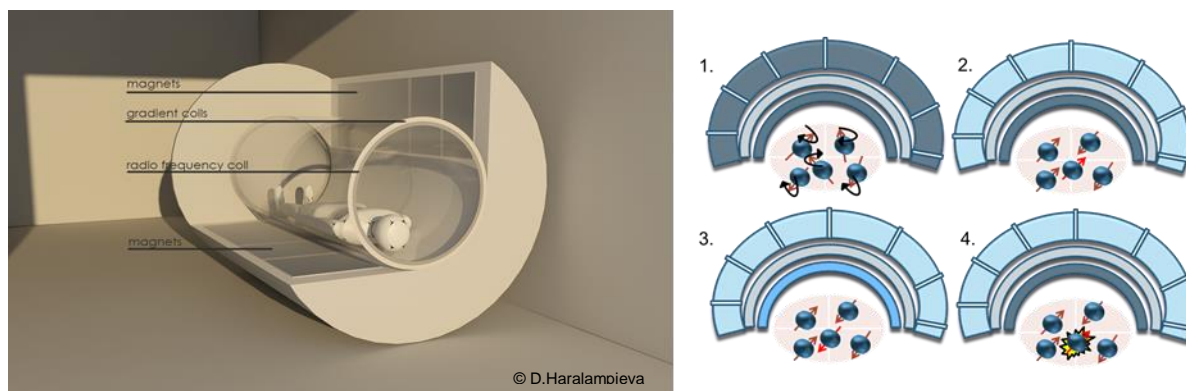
MRI scanner uses radiowaves and strong magnetic fields to obtain anatomical and functional body images. 1) Atoms spin in random directions. 2) Applying a magnetic field makes atoms line up either in the direction of  $B_0$ , or in the opposite direction. The distribution is not exactly equal, as more atoms prefer to turn in “low energy” state, thereby creating a net magnetization parallel to  $B_0$ . 3) Introducing a RF pulse makes half of the “excess” atoms change the direction of their magnetization moment - to the “high energy” state. 4) Turning the RF off makes these atoms turn back to their “low energy” position (relaxation), thereby emitting energy.
